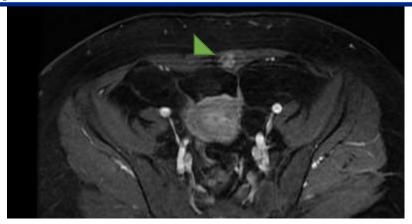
Axial T2 and coronal T1 slices from the pelvic MRI show fibrous thickening with hypointensity T2 , hyperintensity T1 of the blad dome
